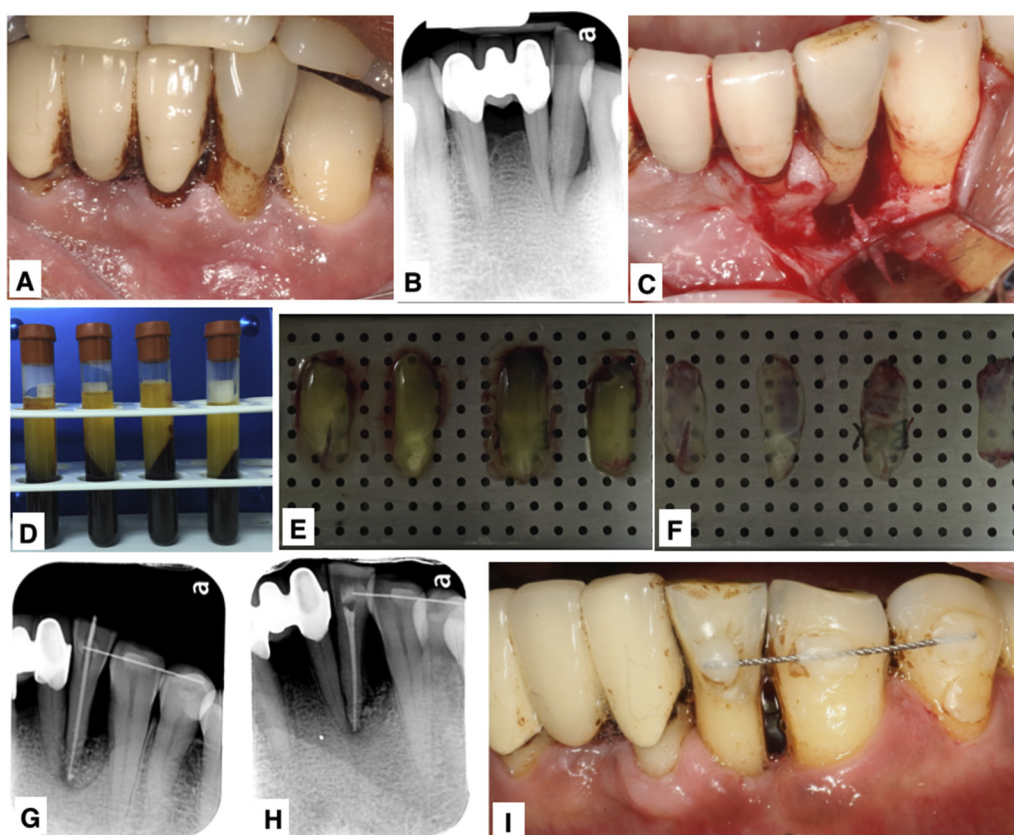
Clinical photographs of the left anterior mandibular sextant. (A) Initial photograph of #32. (B) Initial periapical radiograph of #32. (C) After flap reflection, buccal dehiscence and one-wall combined with two-wall intrabony defect was exhibited. (D) Platelet-rich fibrin (PRF) was prepared and formed in the middle part of the tube. The upper part contained acellular plasma and the bottom part contained red corpuscles. (E) PRF clots were transformed into PRF box. (F) PRF membranes were obtained after condensation on a sterile metal plate. (G) Periapical radiograph after 2 months of follow-up. (H) The periapical radiograph after 6 months of follow-up. (I) Clinical photograph after 6 months of follow-up.
